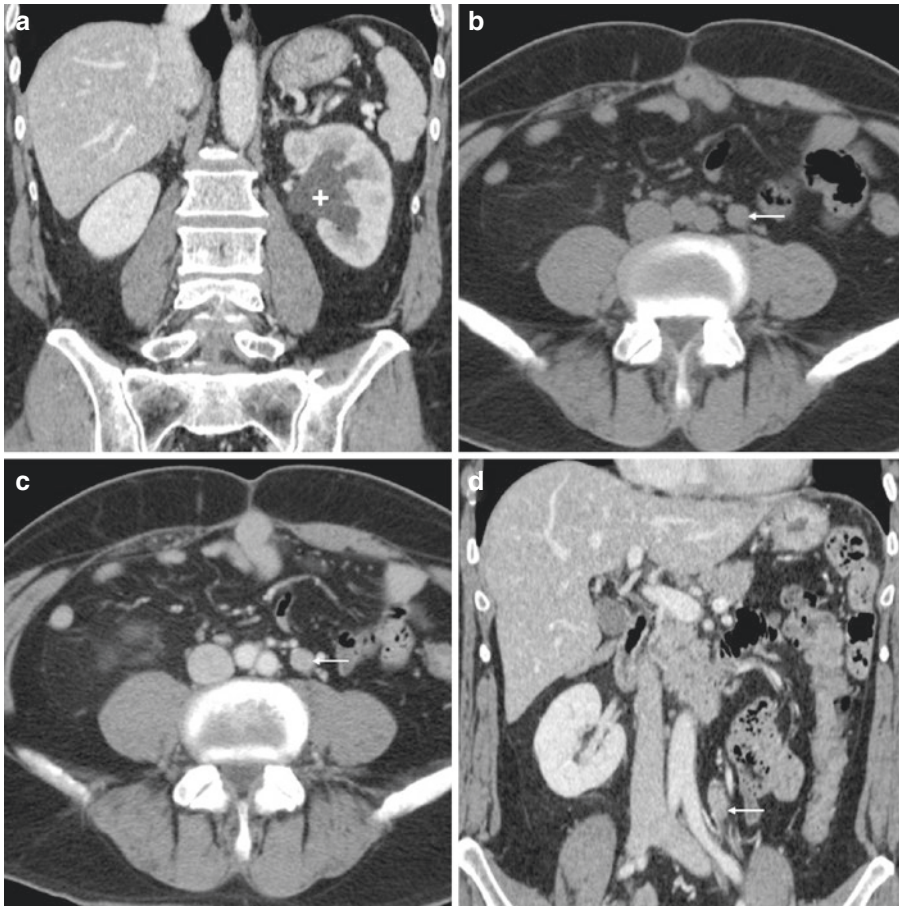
In a 60-year-old male undergoing follow-up for resected colon cancer, multidetector CT (a–d) showed first-degree hydronephrosis (+) with delayed nephrogram on the left side (a). The ipsilateral lumbar ureter (thin
